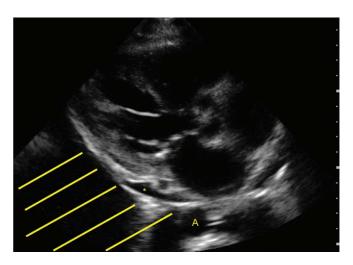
Parasternal long axis window showing a small pericardial and a large pleural effusion. The pericardial effusion (*) is seen anterior to the descending aorta (A), while the pleural effusion (area indicated by lines) is the large anechoic space adjoining and posterior to the descending aorta.
